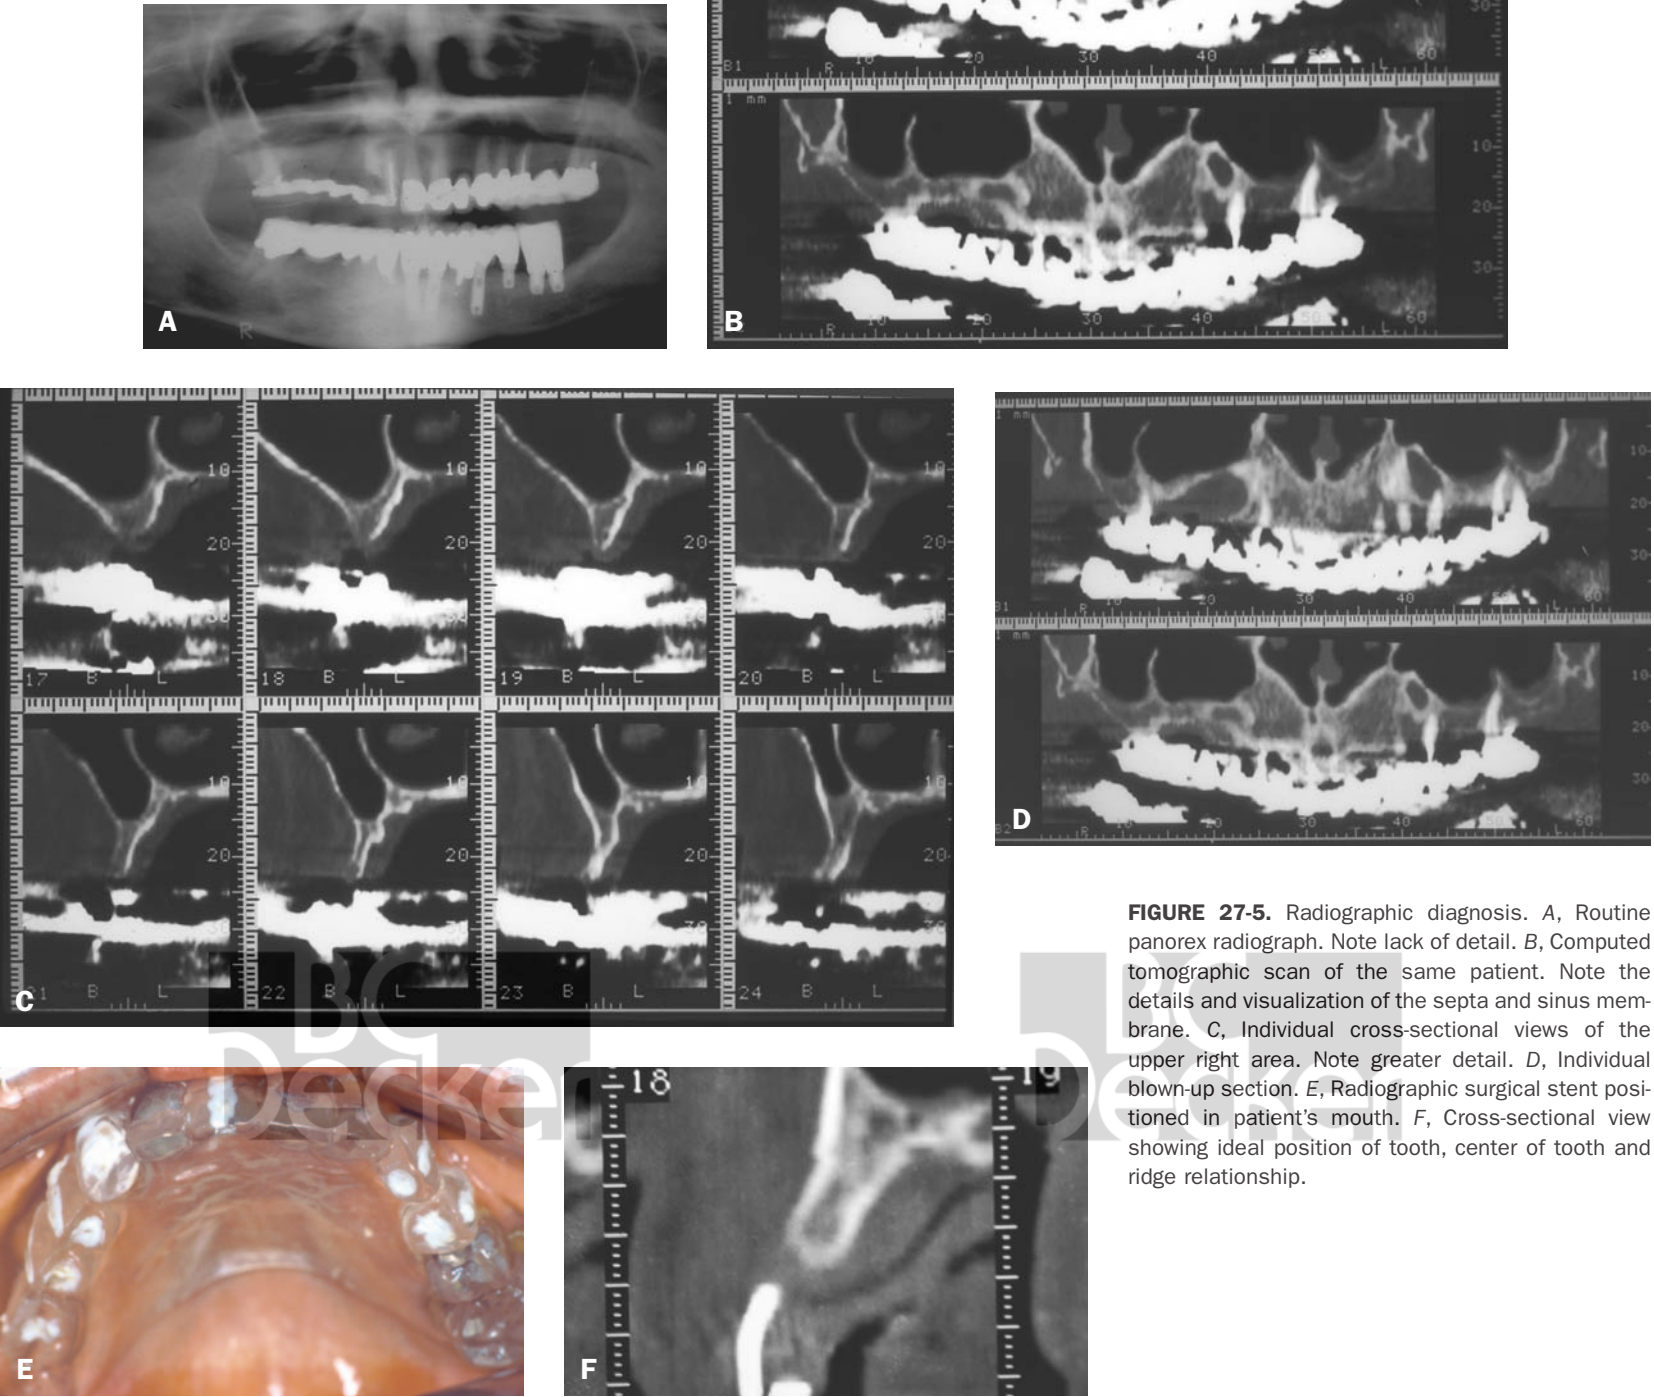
Radiographic diagnosis. A, Routine panorex radiograph. Note lack of detail. B, Computed tomographic scan of the same patient. Note the details and visualization of the septa and sinus membrane. C, Individual cross-sectional views of the upper right area. Note greater detail. D, Individual blown-up section. E, Radiographic surgical stent positioned in patient's mouth. F, Cross-sectional view showing ideal position of tooth, center of tooth and ridge relationship.
